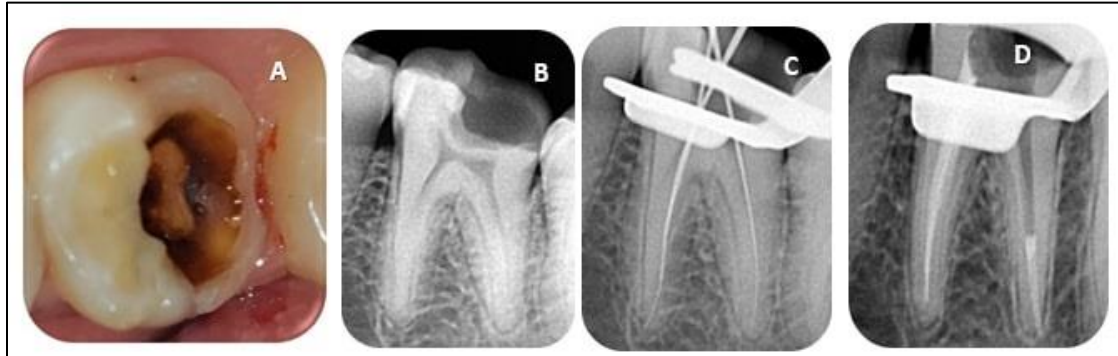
Case- 2: A: Pre-operative clinical photograph #46 B: pre-operative radiograph C: Working length determination D: obturation followed by post space preparation
